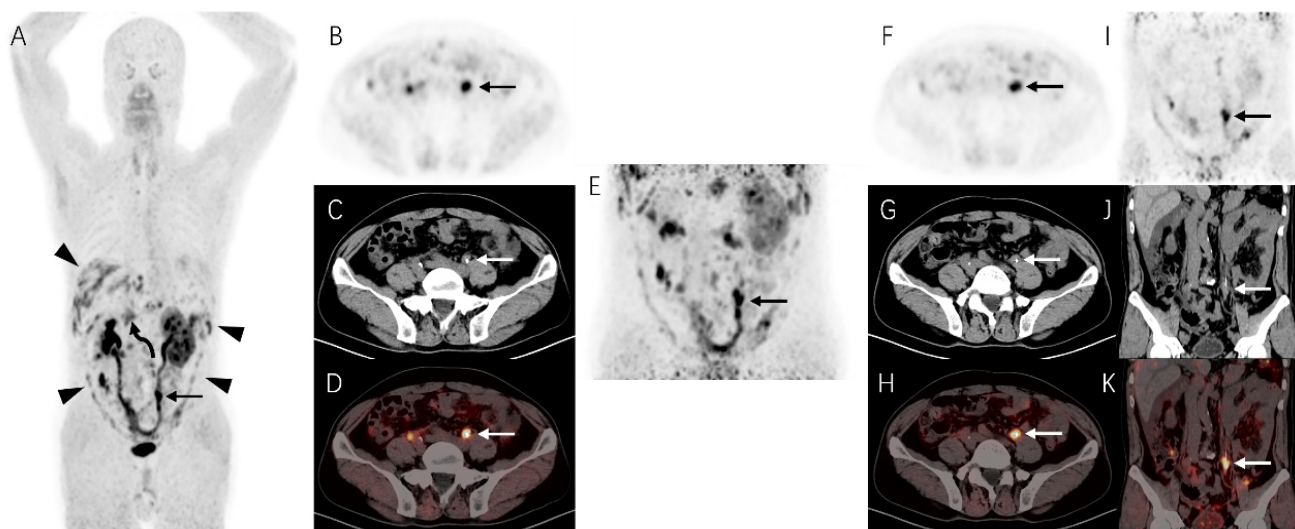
A 55-year-old man was admitted to the hospital due to left back pain for 2 weeks. Enhanced abdominal computed tomography (CT) suggested inhomogeneous thickening of the left ureteral wall with obvious enhancement, as well as peritoneal thickening, which suggested the possibility of left ureteral malignancy with peritoneal metastasis. However, the ureteroscopic biopsy was suggestive of signet ring cell carcinoma. With the consent of the patient, we enrolled him in a clinical trial of gallium-68-labeled fibroblast activation protein inhibitor 4 (^{68}Ga -FAPI-04) study in tumors. The maximum intensity projection (MIP) (A) and axial images (B-D) revealed increased FAPI uptake in the left ureteral wall (solid arrows; maximum standardized uptake value (SUVmax) of 14.1). Delayed images (E) after furosemide (intravenous injection, 10 mg) showed a clearer display of left ureteral lesion (solid arrows; SUVmax of 14.3) with less urinary impact (F-H: axial images; I-K: sagittal images). In addition, multiple thickenings of the peritoneum showed increased FAPI uptake (arrowheads; SUVmax of 13.8). Furthermore, a focus of elevated activity in the middle abdomen (curved arrows) was also noted on the MIP image.
